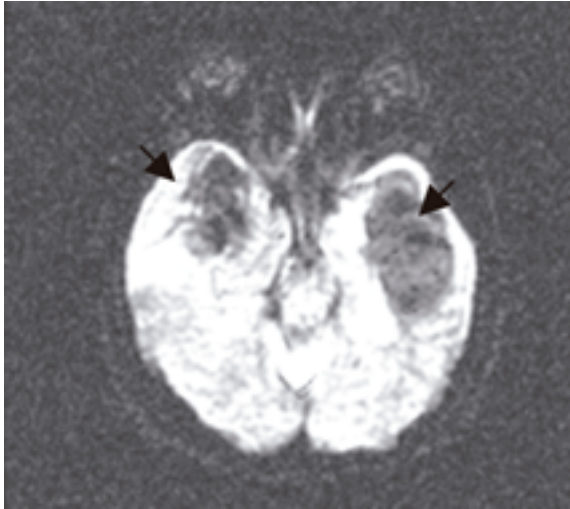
MR DWI shows bilateral hypointense signals in the temporal lobe (arrows), suggestive of temporal lobe radiation necrosis.
